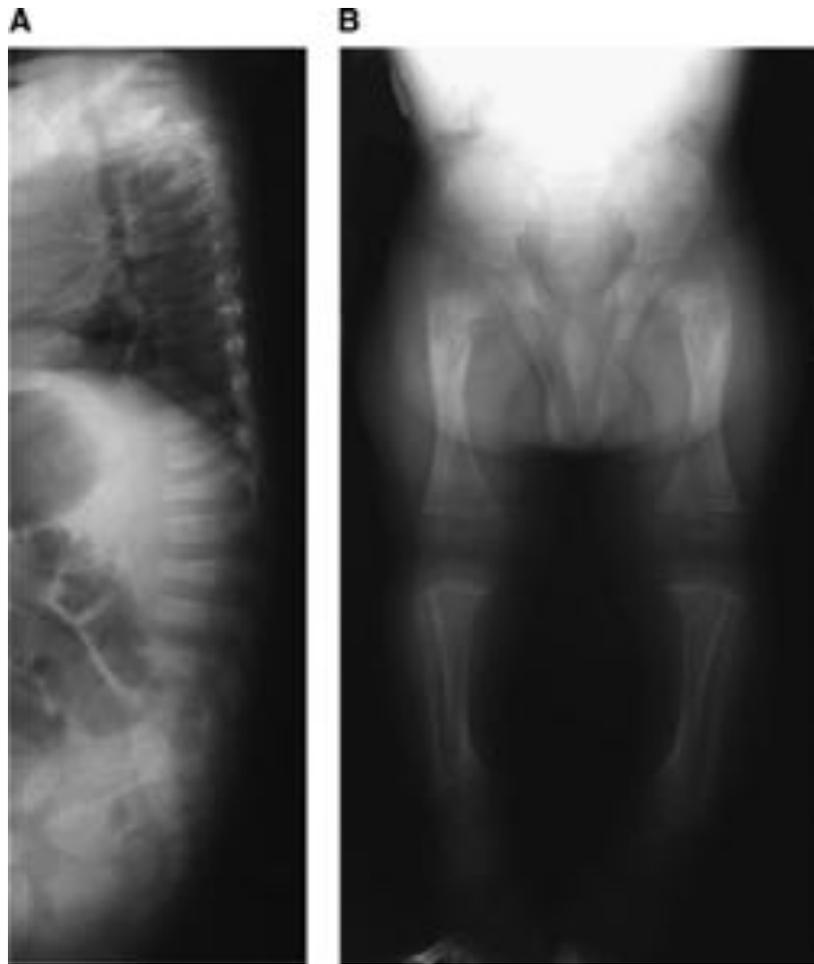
Radiograph examination of the propositus at 4 months old. A: Spinal radiograph showing flattened biconcave vertebral bodies and severe osteoporosis. B: Lower limb radiograph showing the stubby long bones with external periosteal thickening, thin cortices, sclerotic metaphyses, and coxa vara.
